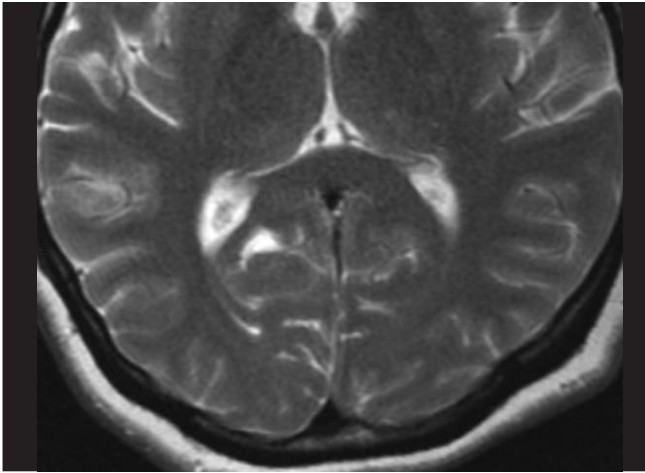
Axial T2-weighted control image showing near-complete regression. There is an encephalomalastic area in the anterior part of the right occipital lobe
